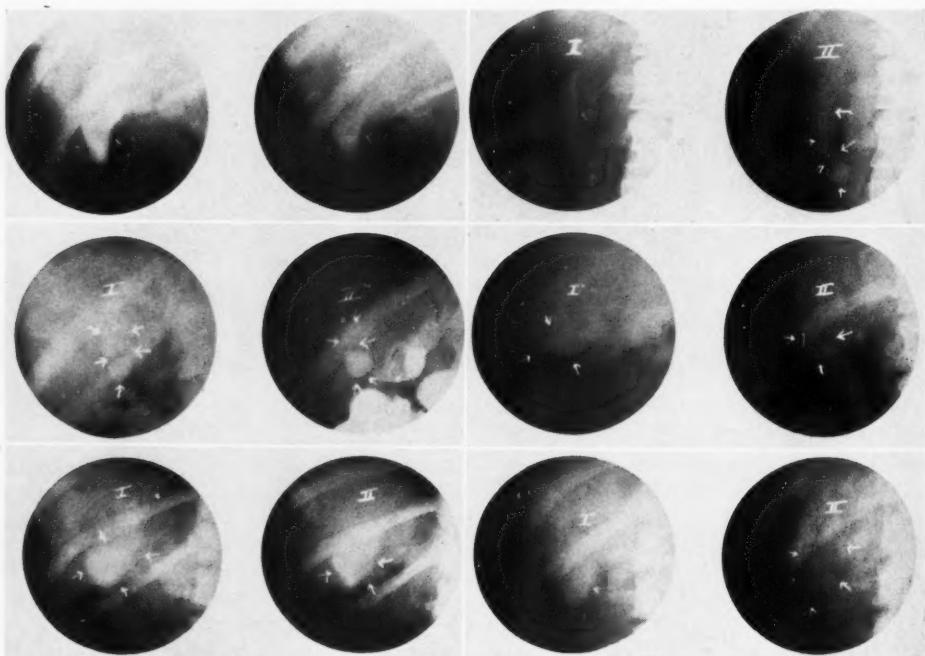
Representative cholecystograms from a series of cases of pericholecytic disease. These are arranged in pairs, No. I indicating the 16-hour roentgenogram and No. II the roentgenogram taken one hour after the fat meal. Note the fade-away emptying, the marked deformity, or the absence of contraction during the contractile phase of the gall bladders.
